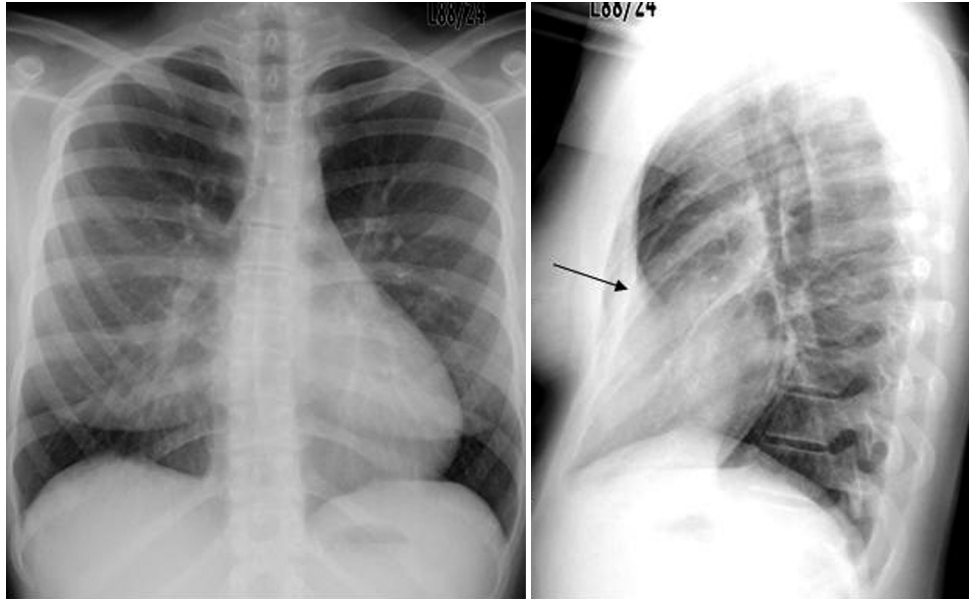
FIGURE e15-6 Routine chest radiographs of a healthy 37-year-old woman. Note the hazy right mediastinal silhouette on the frontal view caused not by cardiac or pulmonary abnormalities but by pectus excavatum (*arrow*), as seen on the lateral view. Note also the normal pulmonary vascular pattern.
